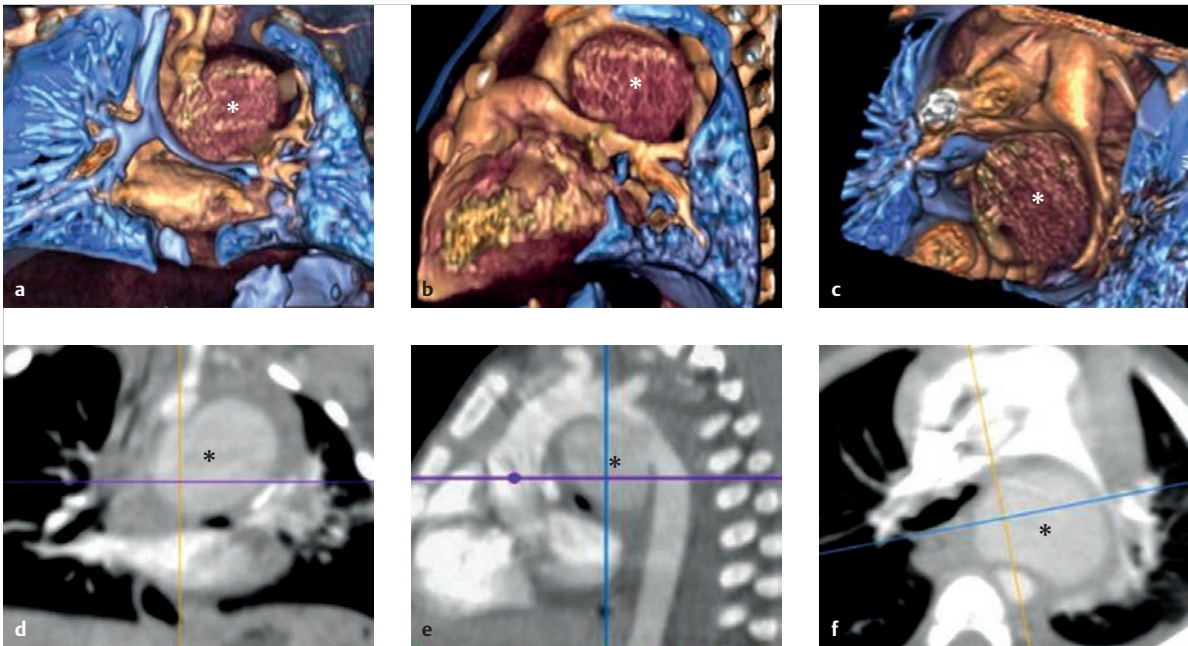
Duct aneurysm. Two-month-old infant with acute respiratory decompensation within the scope of a pulmonary infection. Echocardiography findings raised suspicions of a duct aneurysm. A multi-row CT provided a complete anatomical depiction. The 3-D reconstructions showed a deviation of the trachea to the right and an obstruction in the left main bronchus (blue: air-filled space, reddish: blood-filled or contrast agent-filled vessels; the asterisk indicates the aneurysm). The left pulmonary artery, like the left main bronchus, is also compressed.
